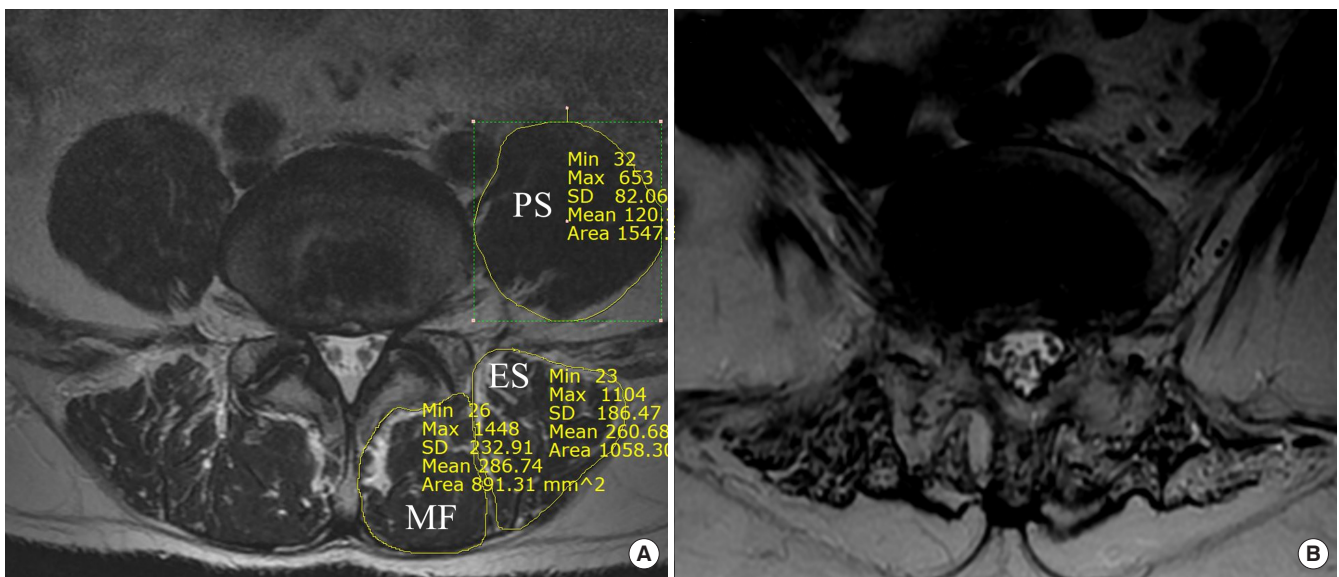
Lumbar spine magnetic resonance imaging (MRI) at the L4/5-disc level. (A) The back and lumbar muscle volumes were measured based on the cross-sectional areas (CSAs) of the lumbar multifidus muscle (MF), lumbar erector spinae muscle (ES), and psoas muscle (PS). (B) Lumbar spine MRI at the L4/5-disc level showing Goutallier classification grade 4. The CSA of MF was 326 mm². SD, standard deviation.
